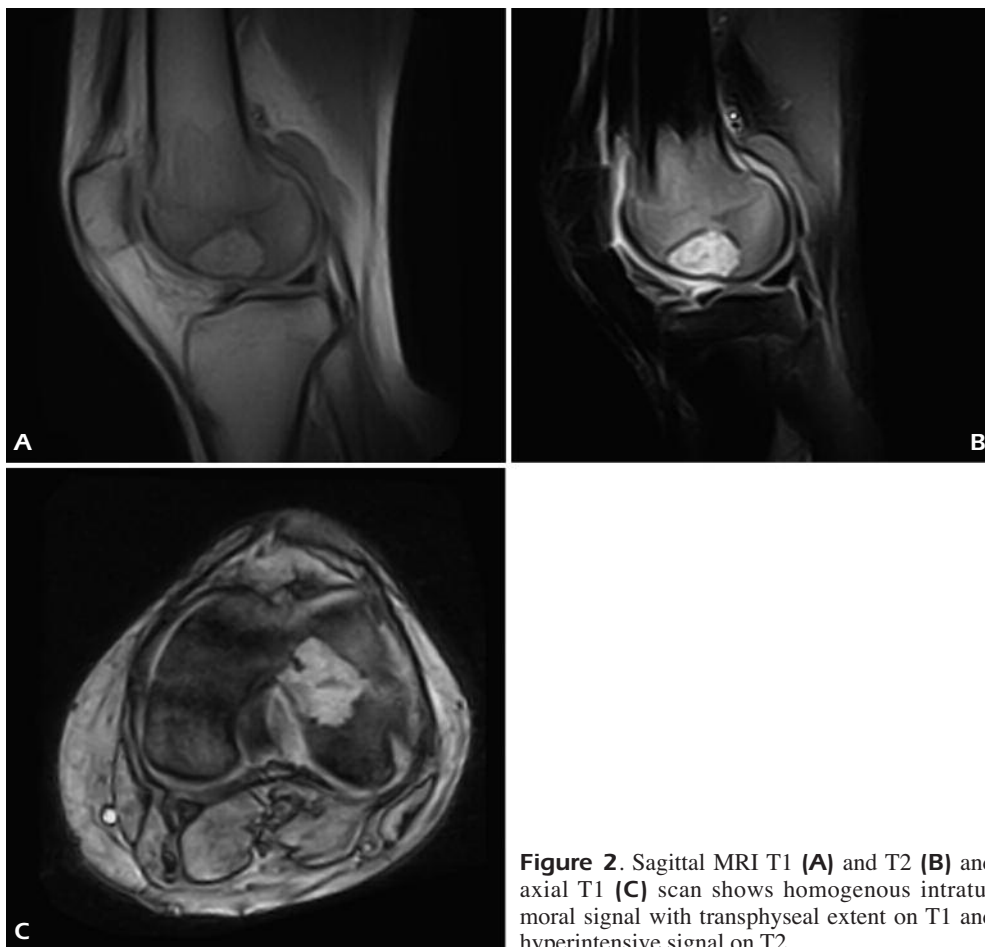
Sagittal MRI T1 (A) and T2 (B) and axial T1 (C) scan shows homogenous intratumoral signal with transphyseal extent on T1 and hyperintense signal on T2.
